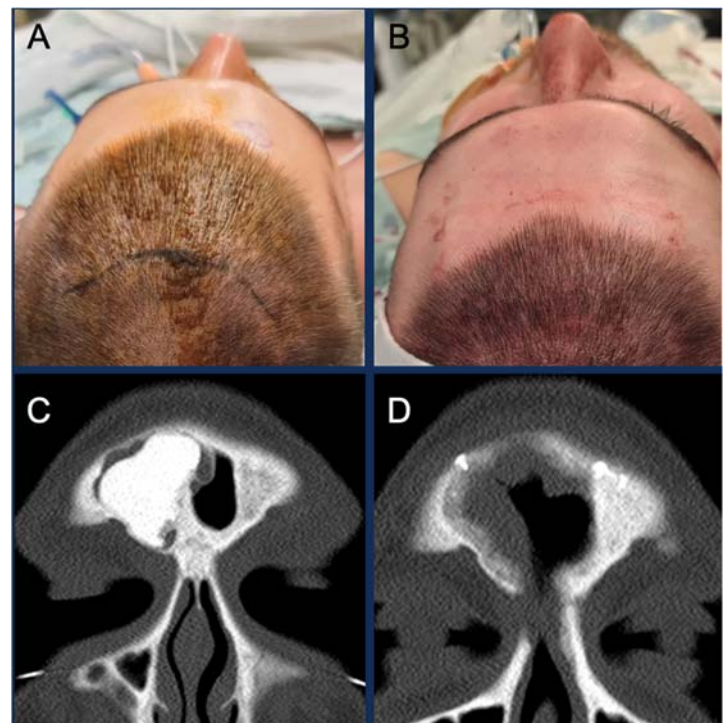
A-B) Pre and postoperative pictures. C-D) Pre and postoperative coronal CT scan 1 month postop. Significant osteitis and mucosal edema of the frontal sinus.
